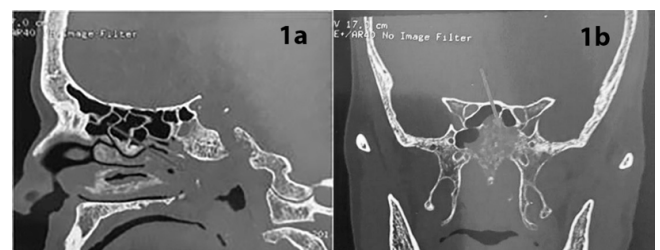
1a: Facial mass CT scan in sagittal section revealing extensive nasal tumor (red arrow)
